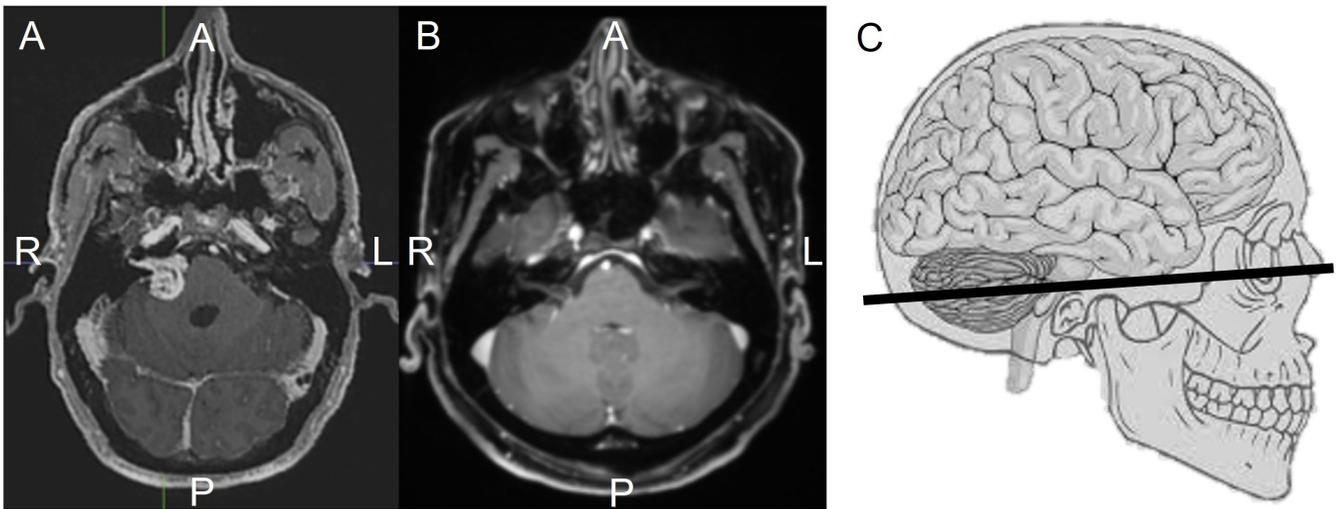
Transverse (axial) MRI images. (A) Eric's MRI and (B) a normal MRI observed at (C) the level of the cerebellopontine angle (the junction between the pons and cerebellum). To orient yourself, note that images of the brain are conventionally viewed from below (inferior view), as if looking up into the head. The patient's anterior (nose-side) is at the top of the image. KEY: R = right, L = left, A = anterior, P = posterior.
